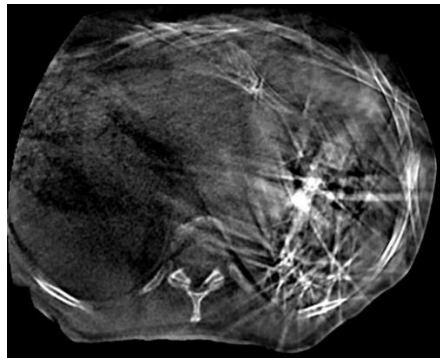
Example of a thoracic CBCT image, notice the low soft tissue contrast combined with important artefacts that strongly degrades the interpretability of the image.
